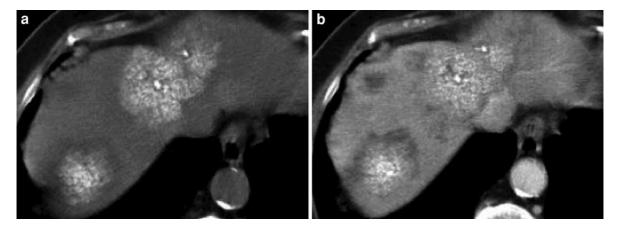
Calcified metastatic liver lesions from mucinous colorectal cancer. a Transverse unenhanced CT image demonstrates two large predominantly calcified masses and a subtle, noncalcified, low attenuation lesion in the right hepatic lobe. b Corresponding contrast-enhanced CT image during hepatic venous shows increased conspicuity of the noncalcified lesion
